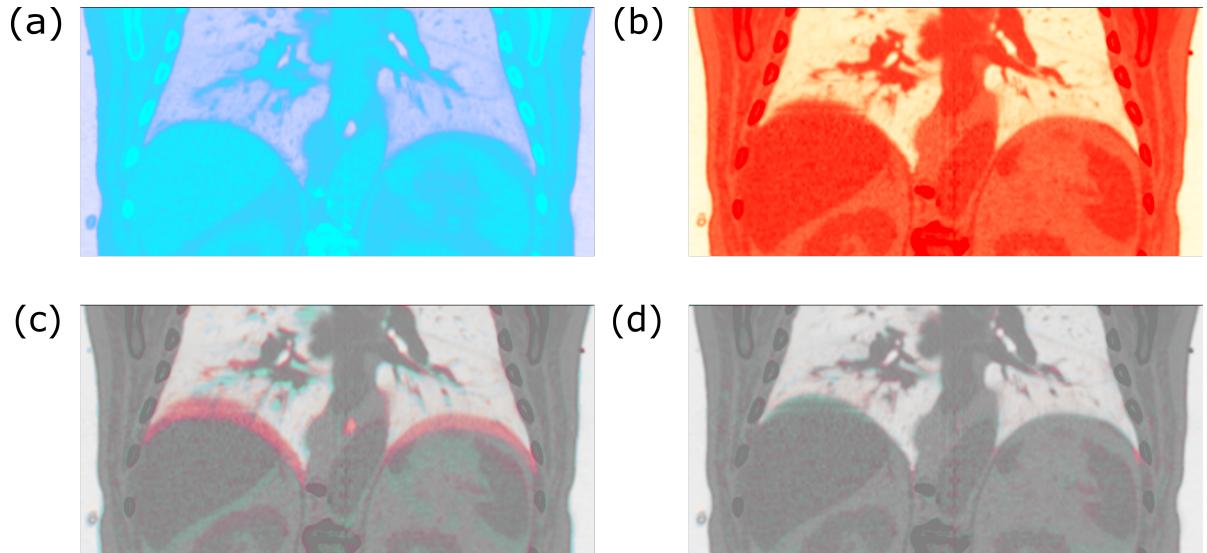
Example of a inverse color overlay. Images (a) and (b) show red and cyan color code, respectively, for a CT scan. (c) displays overlayed inverse colored images before and (d) after registration.
